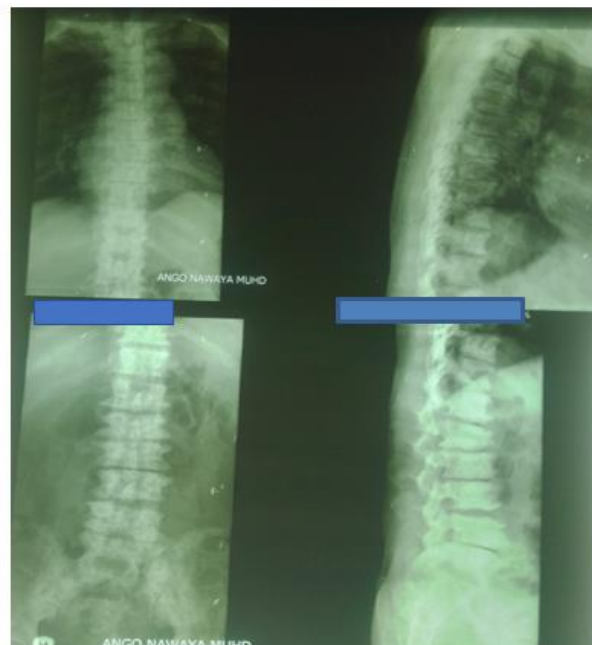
Plain radiographs of the thoracic, lumbar and sacral spine demonstrating diffuse sclerotic changes of the entire bones with moderate-severe degenerative changes of the thoraco-lumbo-sacral bones.
